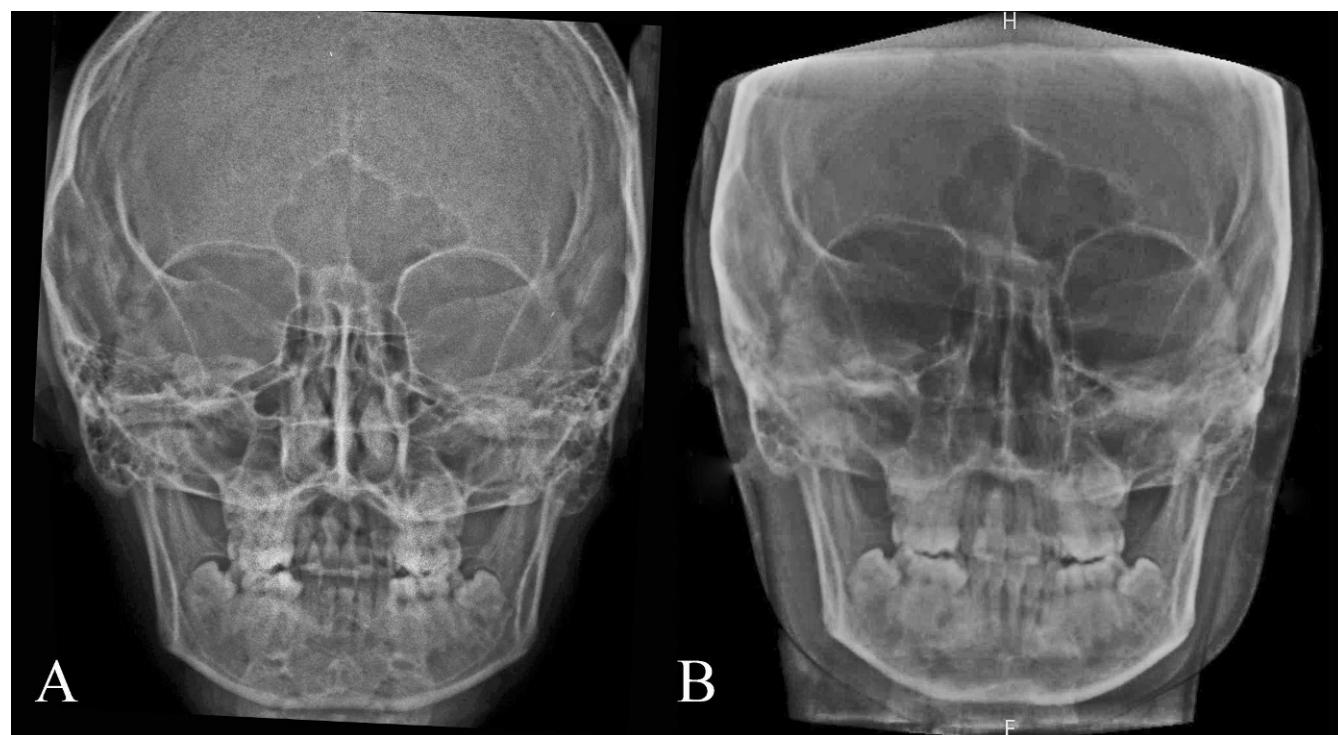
Frontal radiographs of the same patient. (A) Conventional radiograph. (B) CBCT-constructed radiograph.
